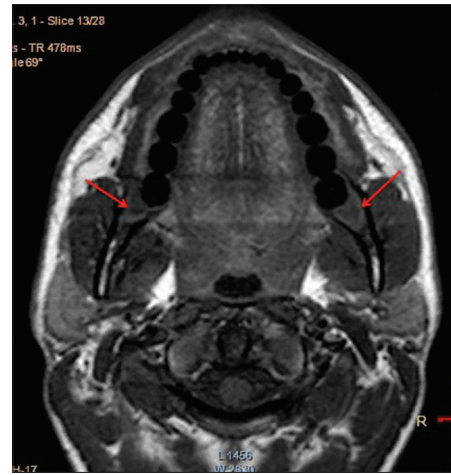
Axial T1-weighted magnetic resonance images showing the hypointense signal intensity of the lesion (arrows) and its real limits
